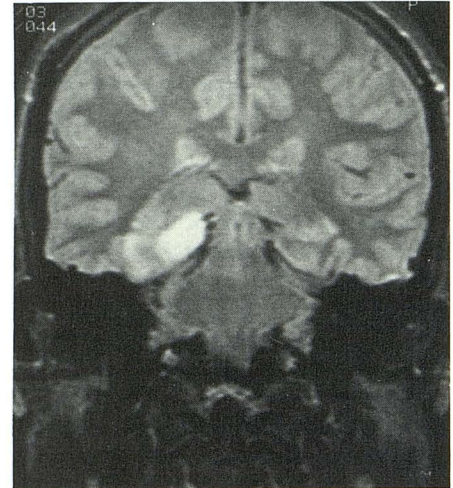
Case 7: 26-year-old man with 1-year history of simple and complex partial seizures. Right temporal lobectomy revealed astrocytoma. Coronal MR image (2500/40) shows severe increase in signal intensity (3+), confined largely to the hippocampus.
